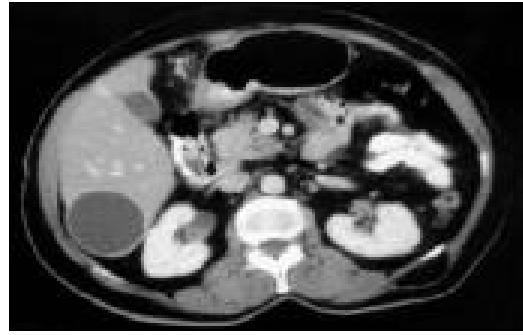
Abdominal CT shows a cyst in the right lobe of the liver.
